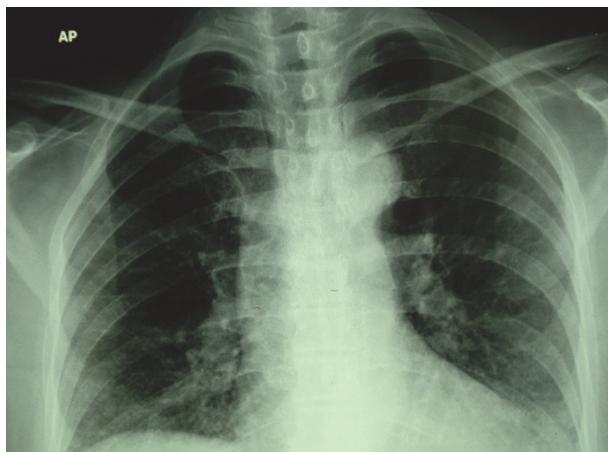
Chest radiography: ground glass and micronodular opacities, predominantly in lower lung fields
